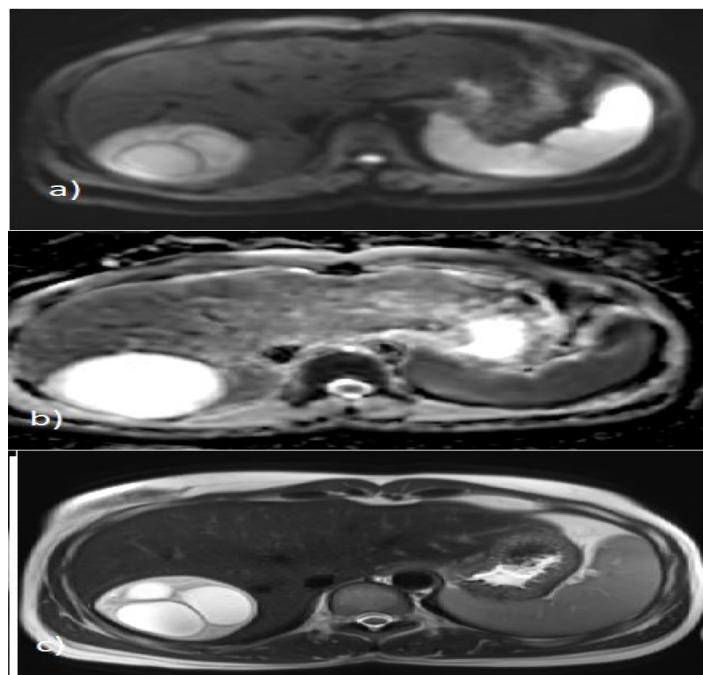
MRI abdomen showing a hydatid cyst in liver; a) & b) Axial DWI and corresponding ADC images showing a large hyperintense lesion in the right lobe of liver with no diffusion restriction. c) Axial T2W images showing loculations with hypointense septations.
